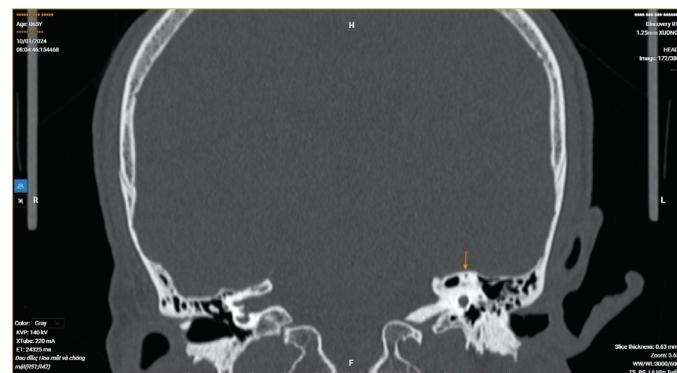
The superior semicircular canal appears intact. Coronal reconstruction of the temporal bone CT scan demonstrates an intact bony roof of the superior semicircular canal (arrow).
